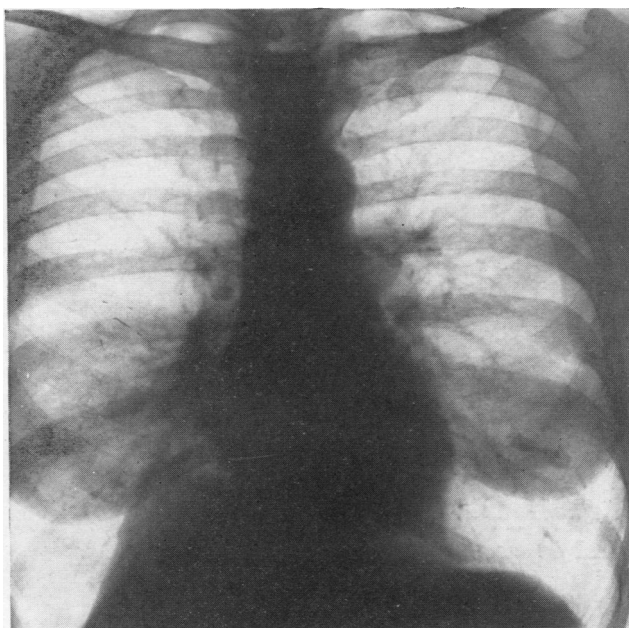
Plain radiograph showing opacity in medial segment of the middle lobe; the diaphragm is raised and distorted. A calcified primary focus can be seen lying in relation to the sixth rib in front. Calcified glands can be seen at the root.
